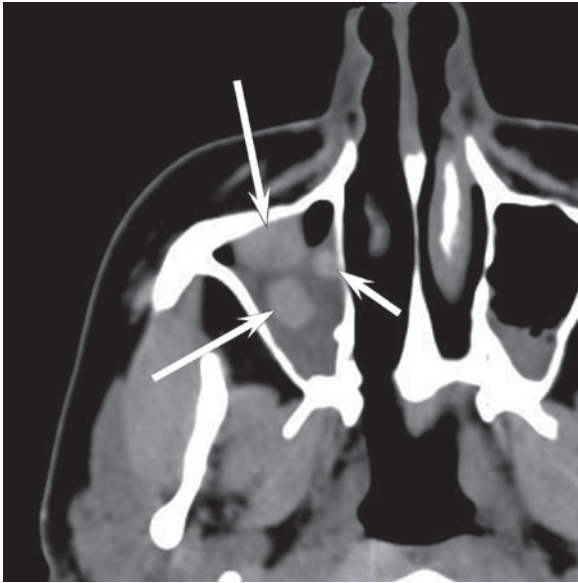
Hyperdense sinonasal polyps. Axial CT shows polyps (*arrows*) within the maxillary sinus. The polyps are denser than the surrounding secretions
